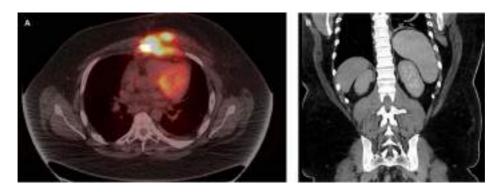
Figure I (A) Pre-treatment PET-CT. (B) Post-cycle I CT abdomen showing splenomegaly.
